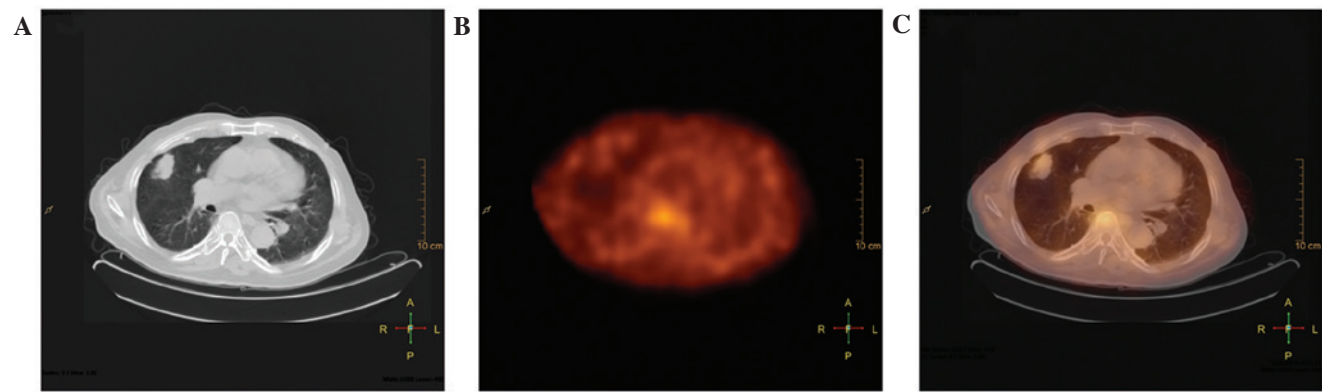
True-negative results for ^{99m}Tc-3P₄-RGD₂ SPECT and SPECT/CT scans, in contrast to a false-negative result for CT. (A) CT, (B) SPECT and (C) CT/SPECT fusion images of a 52 year-old woman (patient no. 21) with a 2.4-cm tuberculoma and low uptake of ^{99m}Tc-3P₄-RGD₂ in the tumor at the middle lobe of the right lung (tumor to non-tumor localization ratio, 1.10). ^{99m}Tc-3P₄-RGD₂, technetium-99m-(polyethylene glycol-4)₃-(Arg-Gly-Asp)₂; SPECT, single-photon emission computed tomography; CT, computed tomography.
